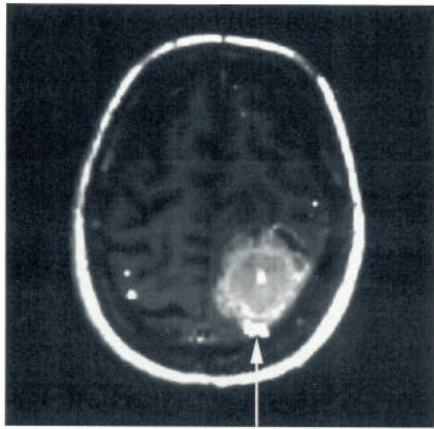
Works-In-Progress. A functional MRI study shows displacement of the motor cortex (arrow), courtesy University of Muenster.
